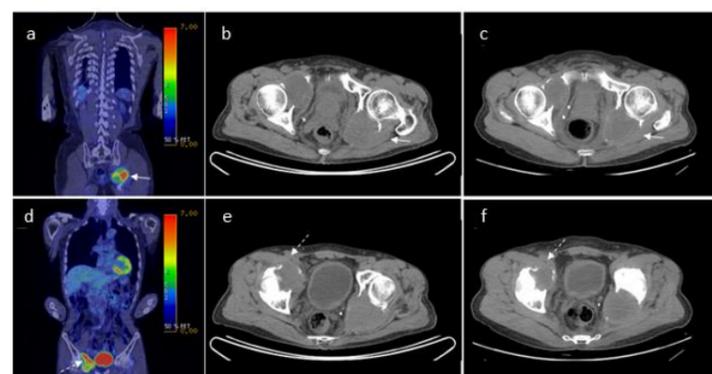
A 72-year-old male patient with pelvis metastases from left (solid arrow) and right (dash arrow) sides. The total longest diameter of pelvis metastases were decreased from 121 mm to 112 mm ten months after RAI-AT (-7.8% change defined as Non-PD). Average SUV_{max} (7.9), sum SUV_{max} (15.7), maximum SUV_{max} (7.9), sum SUV_{max} (15.7), maximum MTV (183.0), average MTV (179.5), sum MTV (359.0), maximum TLG (950.4), average TLG (887.0) and sum TLG (177.4) before treatment showed an extremely high values. However, maximum SUV_{max} showed the value of 8.1 lower than the cutoff of 9.12.
